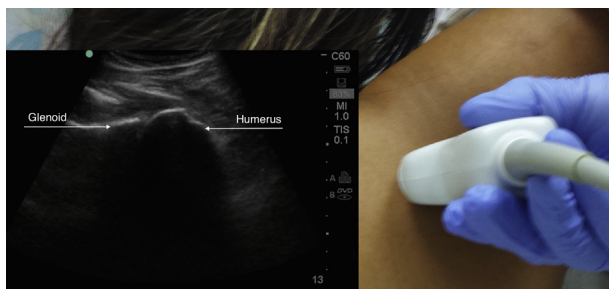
Posterior approach to viewing the glenohumeral joint with arm held in abduction. The glenohumeral joint on ultrasound with probe indicator lateral to the patient.
